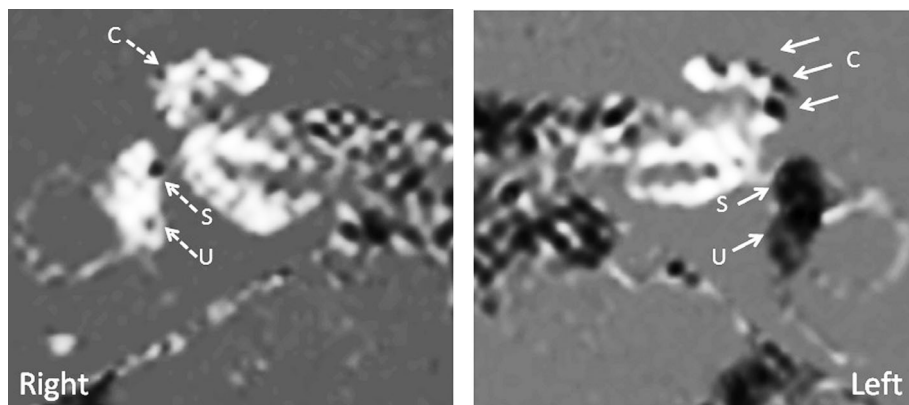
A 55 years old man of MD on the left ear, with four-tone average of 71 dB (stage IV). Hydrops MRI on the left ear demonstrates Grade II hydrops at the cochlea (C), and Grade III hydrops at the saccule (S) and utricle (U). Right ear, control. Solid arrows: present hydrops; dashed arrows: no hydrops.
